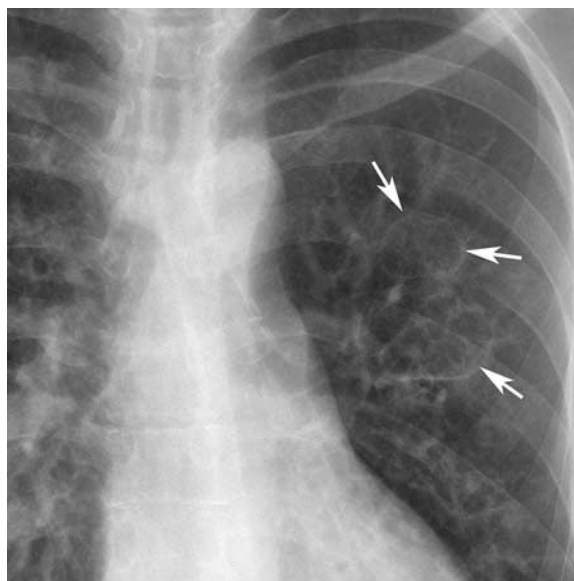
Pneumatocoles. Anteroposterior chest radiograph of a 58-year-old man with a previous *Staphylococcus aureus* pneumonia shows multiple sharply defined cysts (pneumatocoles) in the left upper lobe (arrows).
